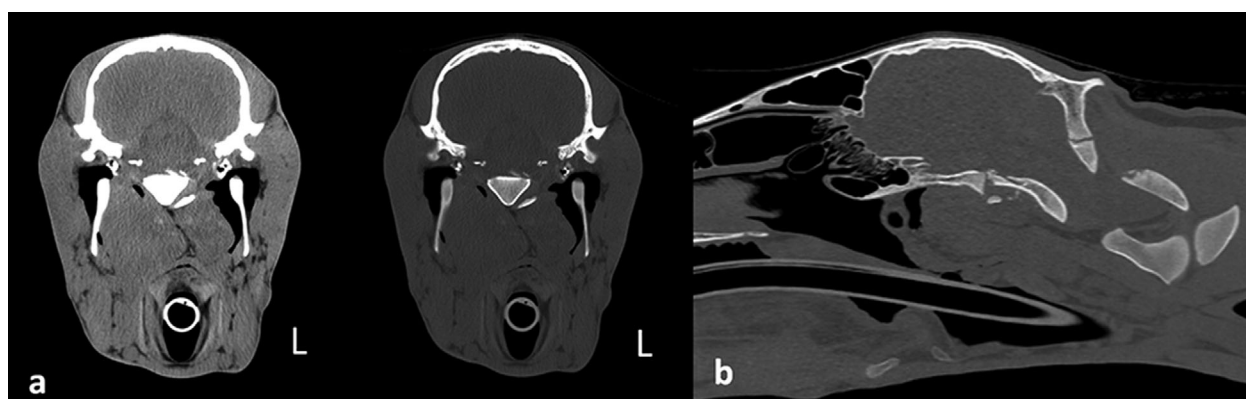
Slices of CT scan study of the head of case 1: (a) transverse views – on the left, the soft tissue algorithm and on the right, the osseous algorithm. The left side of the patient is on the right side of the images; (b) sagittal slice in the bone window. The two biggest fragments of the comminuted fracture of the basisphenoid-basioccipital physal junction are evident in these images
